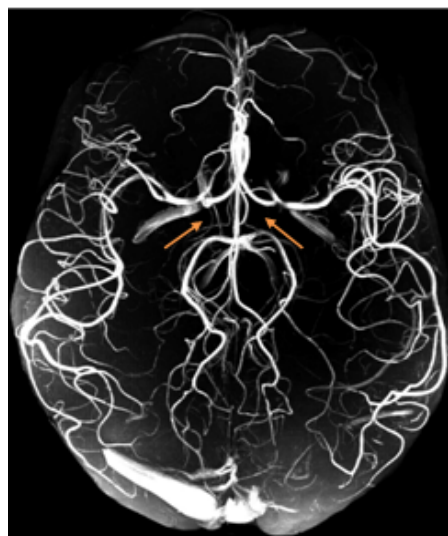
a) MIP of high-resolution whole-brain TOF MRI of a healthy female. Variant with absence of both posterior communicating arteries can be clearly seen (arrows). b) High-resolution SWI optimally depicts cerebral veins.
